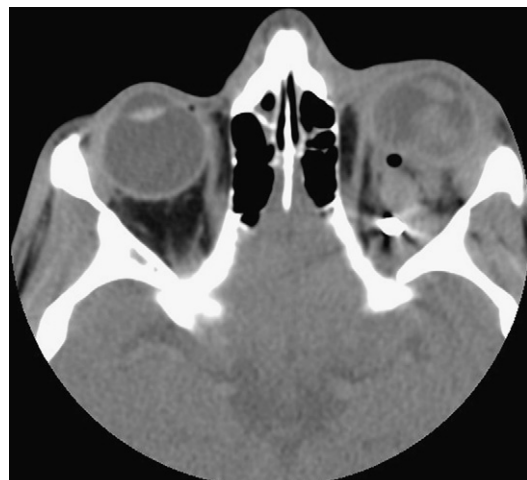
Axial CT demonstrating large intraorbital foreign body. Air is present behind globe suggesting posterior globe rupture.
